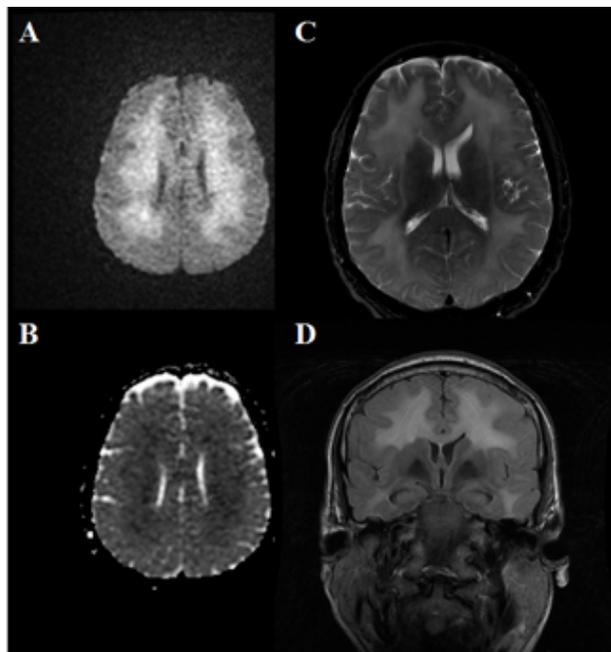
Axial and coronal MRI brain sequences demonstrating increased signal on diffuse weighted sequences in the bilateral subcortical white matter (A) without corresponding increased signal on apparent diffusion coefficient sequences (B) and corresponding mild, diffuse, bilateral, symmetric T2-weighted (C) and FLAIR (D) hyperintensities sparing the subcortical U-fibers and not extending into the cerebellum and brainstem without associated contrast enhancement (not shown).
